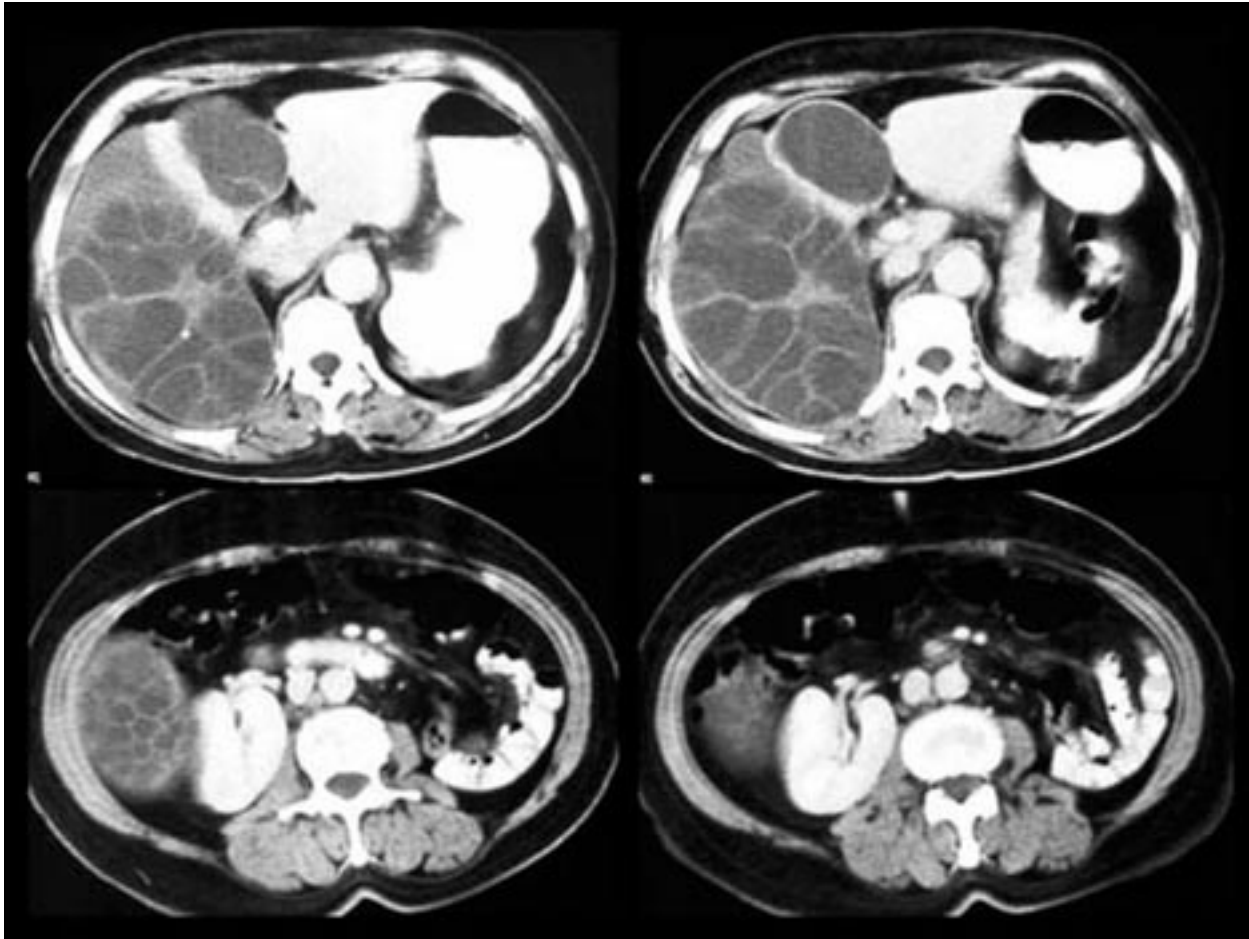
(A-D). Contrast-enhanced CT images.
